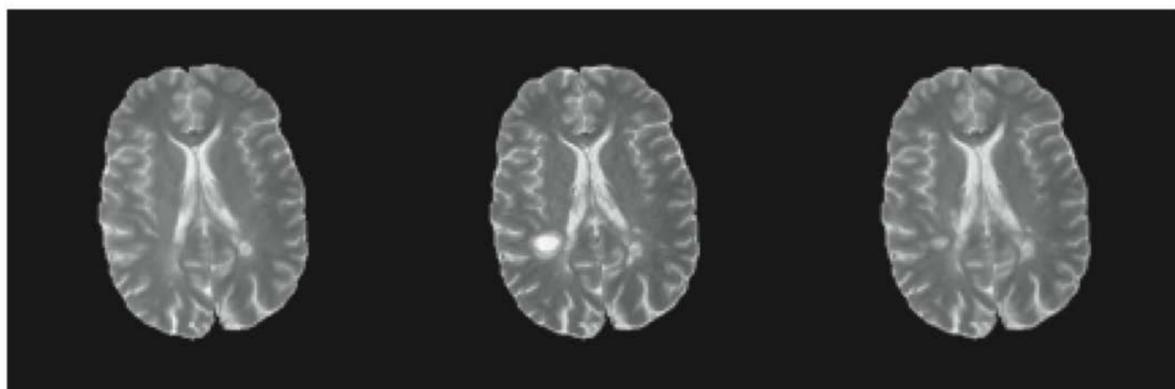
Three-dimensional magnetic resonance images of the brain at three different time points in the course of MS. Left, early; center, during acute exacerbation; right, after therapy. The technique used causes fluid to appear white. The lateral ventricles in the middle of the brain scan and the sulci of the cerebral cortex around the edge appear white as a result of normal cerebrospinal fluid. The white spots, which are due to edema fluid and decreased myelin, are MS lesions.
